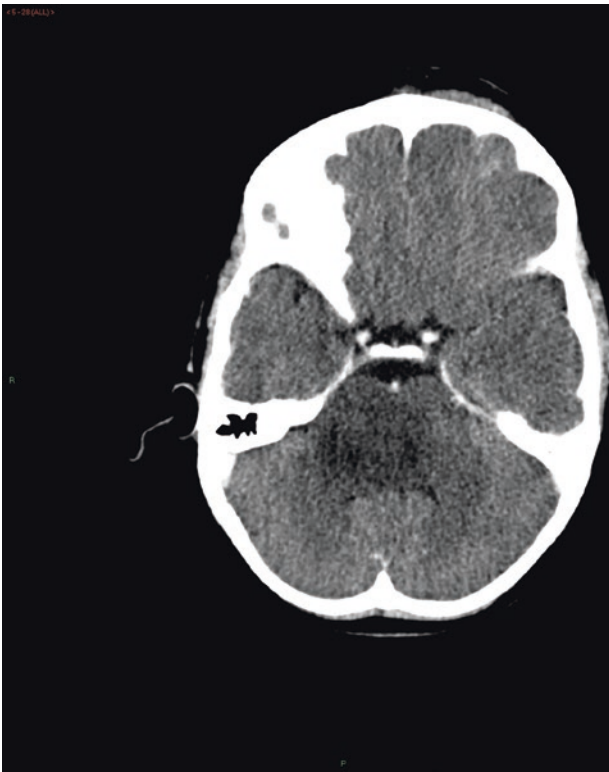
Diffuse pontine glioma. Axial contrast-enhanced CT image shows a low-attenuation lesion expanding the pons. The enhancing basilar artery lies anterior to the swollen pons. The fourth ventricle is effaced
